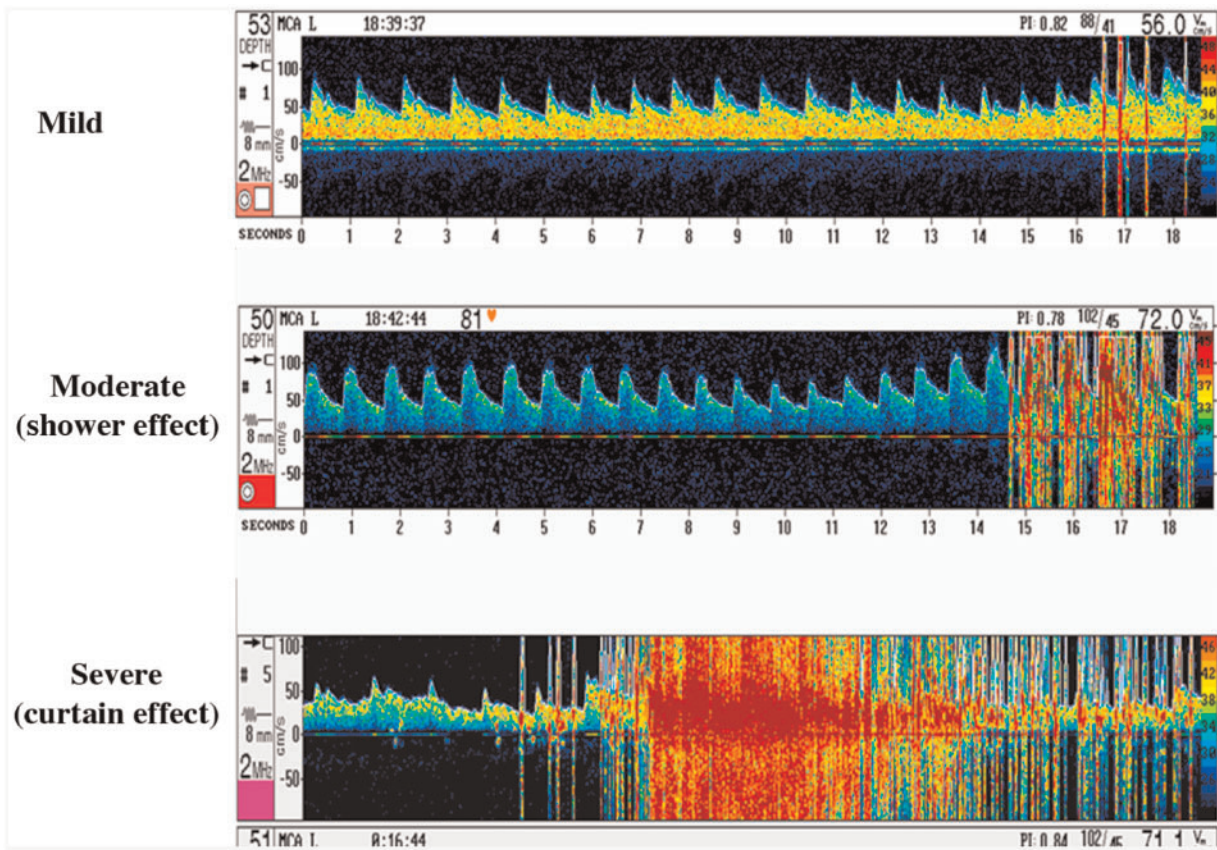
Contrast enhanced transcranial Doppler patterns in patients with various degrees of right-to-left shunt. MCA, middle cerebral artery. Reproduced with permission from Gonzalez-Aluja *et al.*²³
